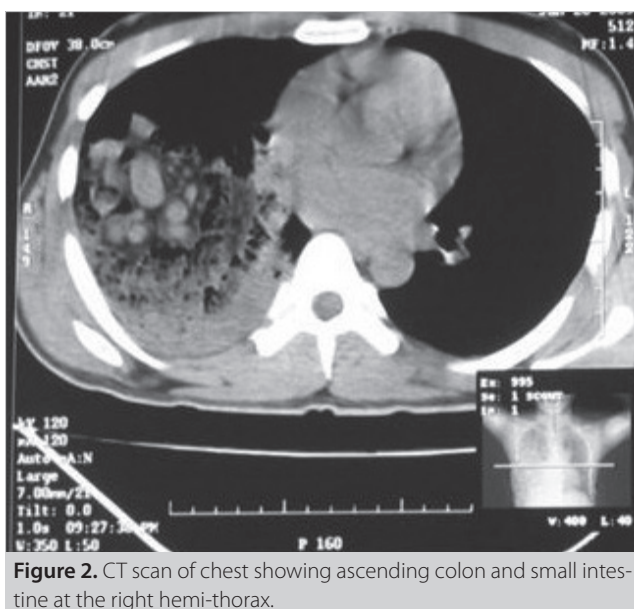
CT scan of chest showing ascending colon and small intestine at the right hemi-thorax.
